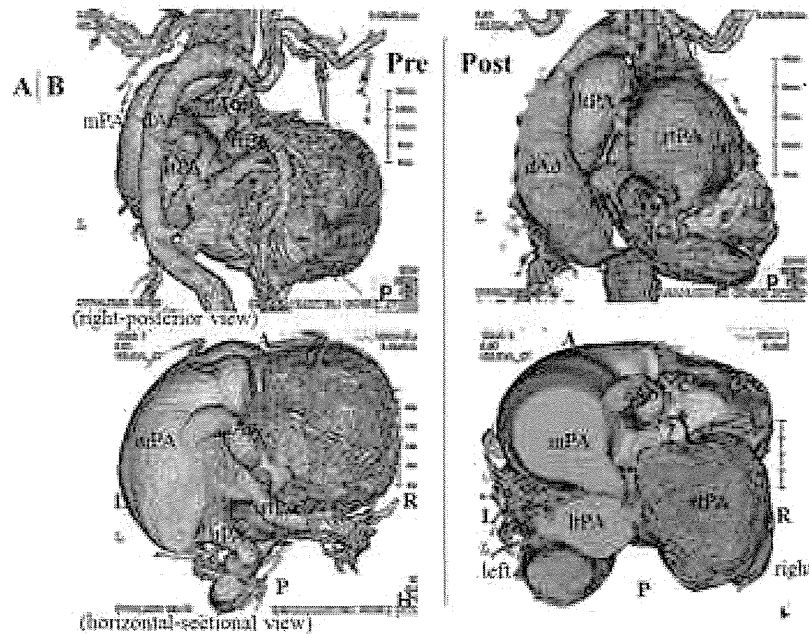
Computed tomography (day 0) shows the interruption of the aortic arch and aneurysmal main pulmonary artery before operation (a). Computed tomography (day 18) shows progress of the significant expansion of the right and left pulmonary arteries and descending aorta after operation (b). A = anterior; aAo = ascending aorta; dAo = descending aorta; L = left; ltpa = left pulmonary artery; P = posterior; mPA = main pulmonary artery; rtPA = right pulmonary artery; R = right.
